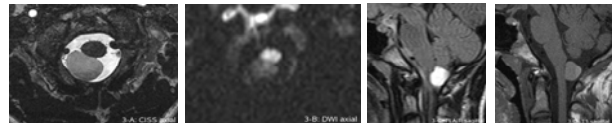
Approximately 1.6 x 1.9 x 1.2 cm, extra-axial, cystic lesion posterior to the medulla right of the midline. Hyperintense signal in the FLAIR sequence (C, sagittal) compared to CSF and brain tissue. Relatively rich signal in T1WI (D, sagittal). In the CISS sequence (A, axial) slightly hypointense compared to CSF, but hyperintense to the brain tissue. No restriction in DWI (B, axial).
